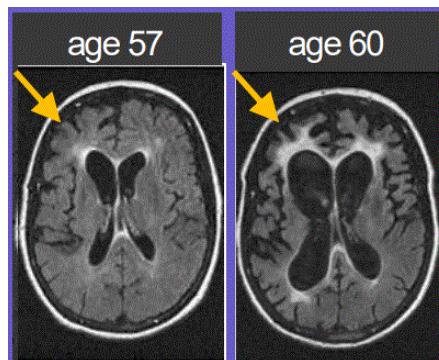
MRI of frontal and temporal atrophy in FTD.
